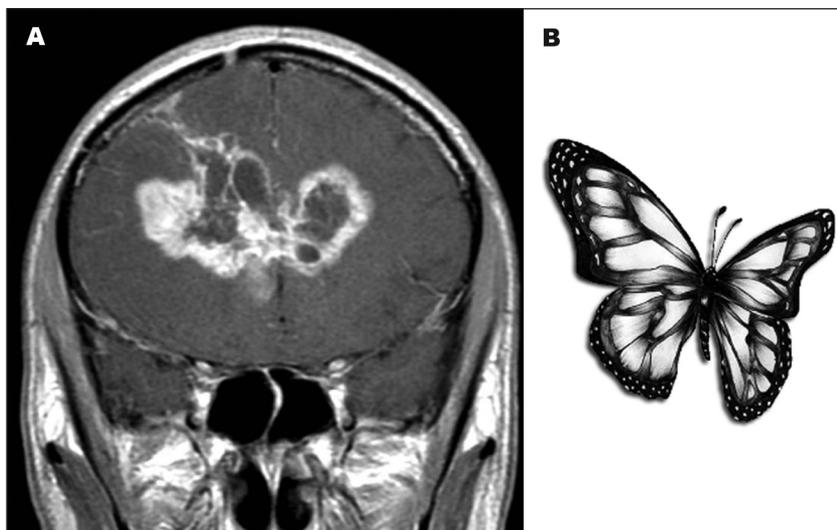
T1-weighted contrast enhanced coronal MR imaging showing an irregular lesion hypointense at the centre with hyperintense margins invading the frontal lobes [A]. The pareidolic aspect of a butterfly is remarkable [B].
